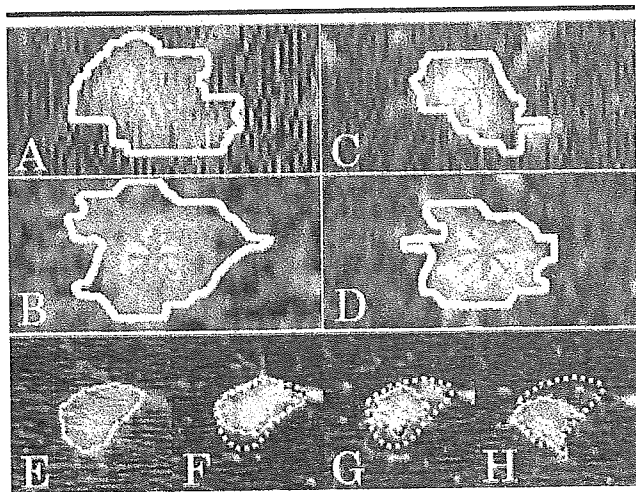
Patient 5. Pulmonary metastasis of adenoid cystic carcinoma. Coronal (A, C) and sagittal (B, D) images from long-scan-time CT (A, B) and thin-section CT (C, D) show tumor with extremely irregular contours. (C and D are approximately in the same plane and at the same level as A and B, respectively.) Transverse image obtained with long-scan-time CT (E) shows contour (outline) of visualized internal target volume. Transverse images obtained with thin-section CT (F, at a level 2 mm above that in E; G, at the same level as E; and H, at a level 2 mm below E) show the target volume with contour lines from E (dotted outlines) superimposed for comparison.
